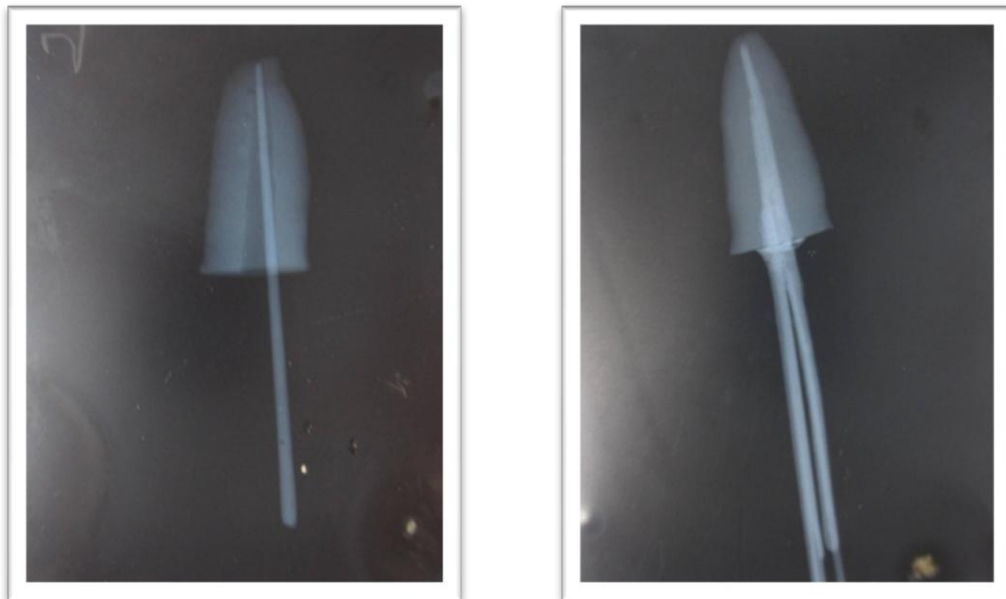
8 Radiographic picture of master cone verification and obturation
